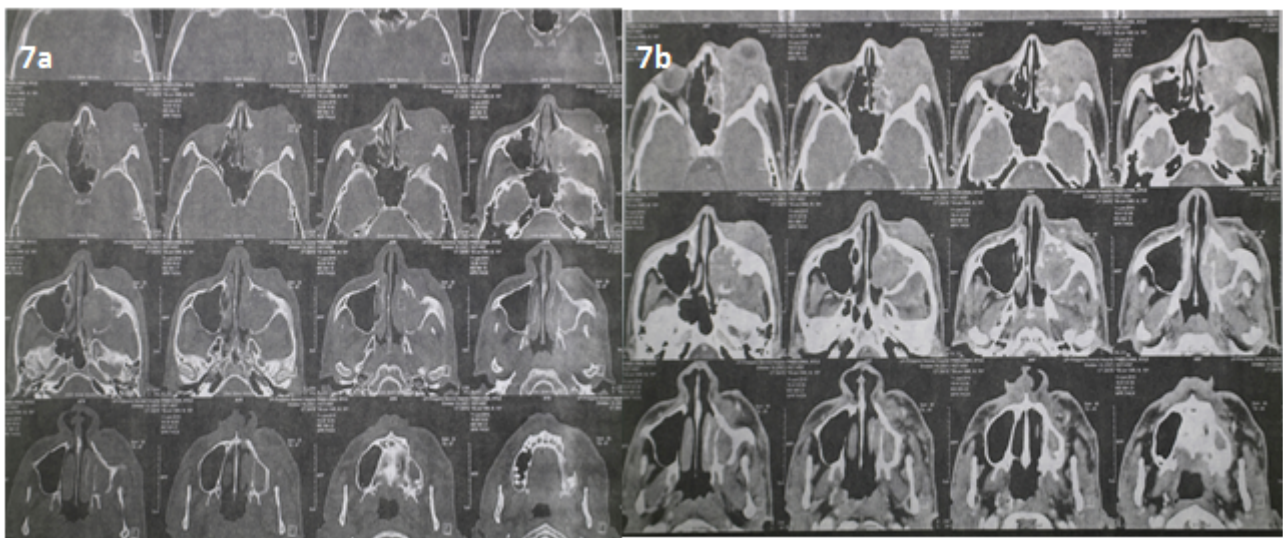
(a) Facial CT scan with Orbital cuts, Axial View, bone window showing proptosis of globe and maxillary sinus and ethmoid bone lysis (b) Facial CT scan with Orbital cuts, Axial View, showing proptosis of globe and maxillary sinus and ethmoid bone lysis and homogenous mass occupying the retroorbital area and maxillary sinus.
